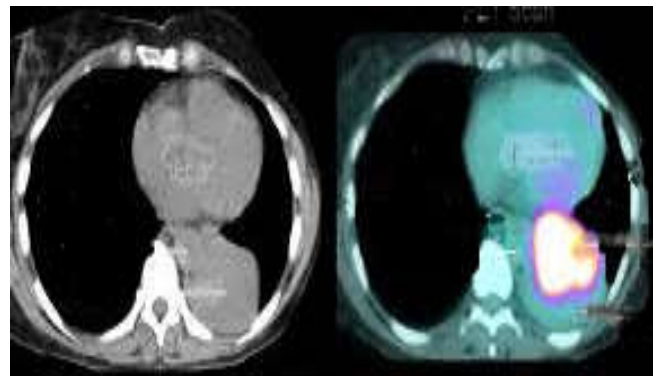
a. CT scan lung imageb. MRI pulmonary epidermoid carcinoma of lungc. PET/CT scan of lung
